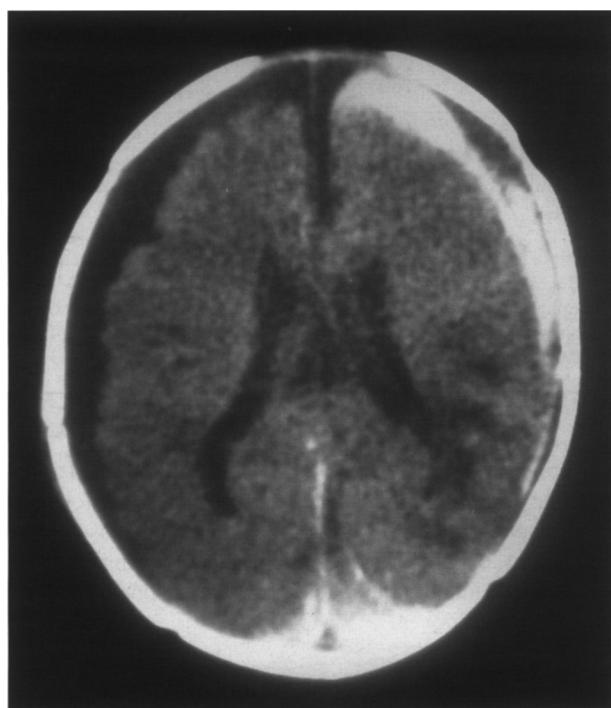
Axial non-enhanced CT through the brain in a child who suffered non-accidental injury demonstrating acute on chronic subdural haematoma on the right with chronic subdural on the left. The acute haemorrhage is seen as high density against the low density chronic blood.
